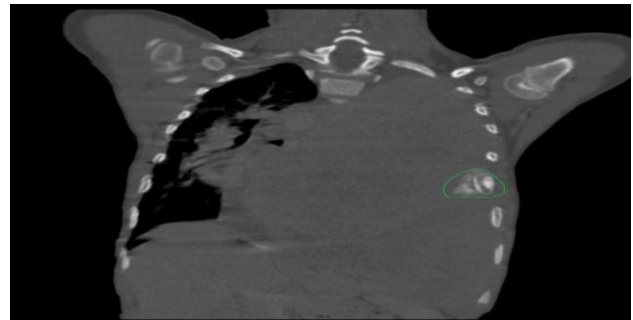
Coronal CT bone window showing a soft-tissue mass arising from the left sixth rib (green circle).
